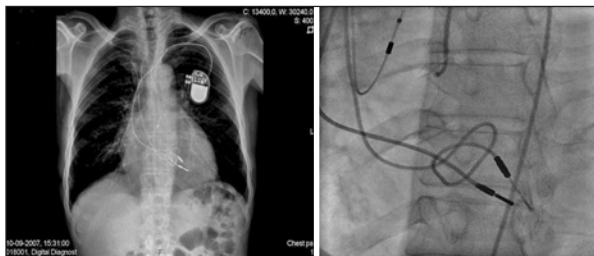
A) Posterior-anterior Chest X-ray demonstrates two pacemaker leads crossing the tricuspid valve with a redundant loop of the original ventricular lead. B) Ventricular pacemaker leads best visualized in the left anterior oblique view at right coronariography.
